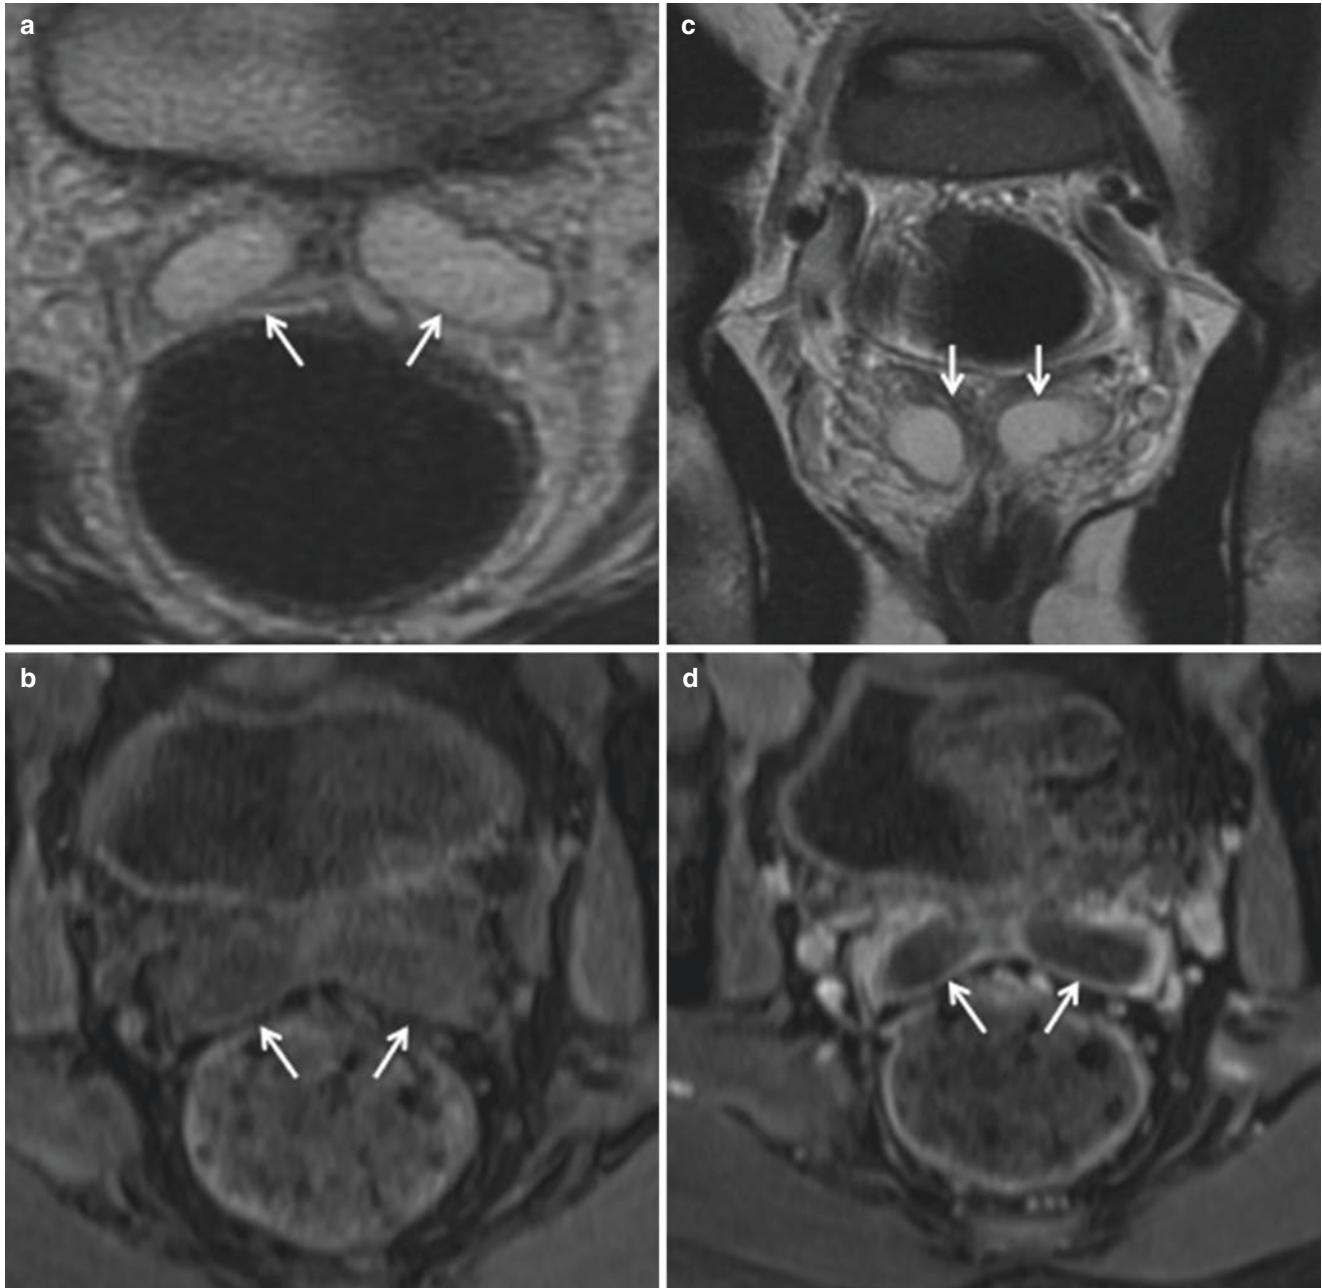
Bilateral SV cysts in a 30-year-old man with infertility. Axial (a) and coronal (c) T2-weighted MR image shows bilateral SV cysts (arrows). Axial (b) T1-weighted MR image obtained with fat
